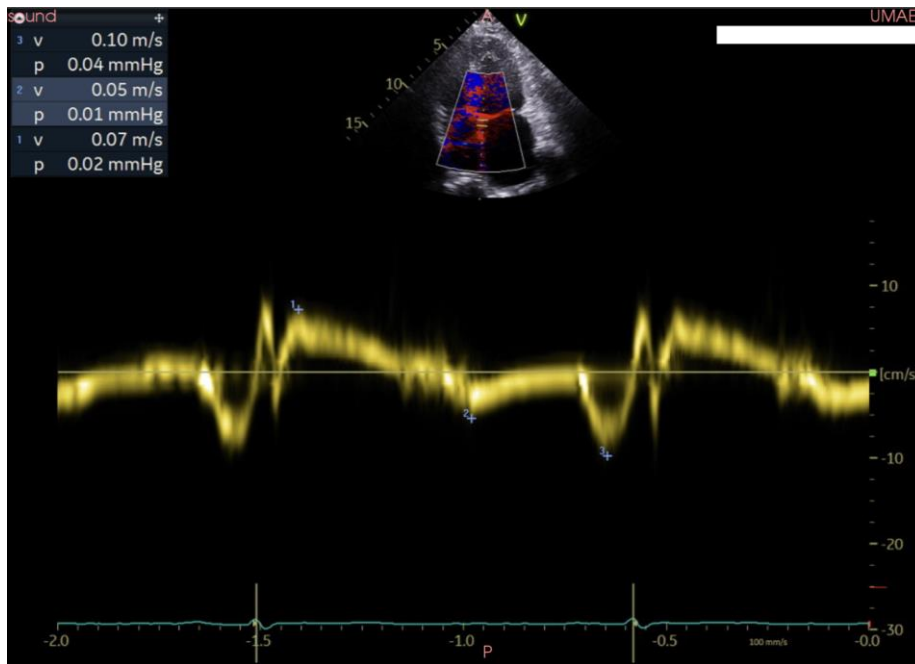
In the apical four-chamber view, tissue Doppler shows a decrease in the septal “e” wave by 5 m/s
